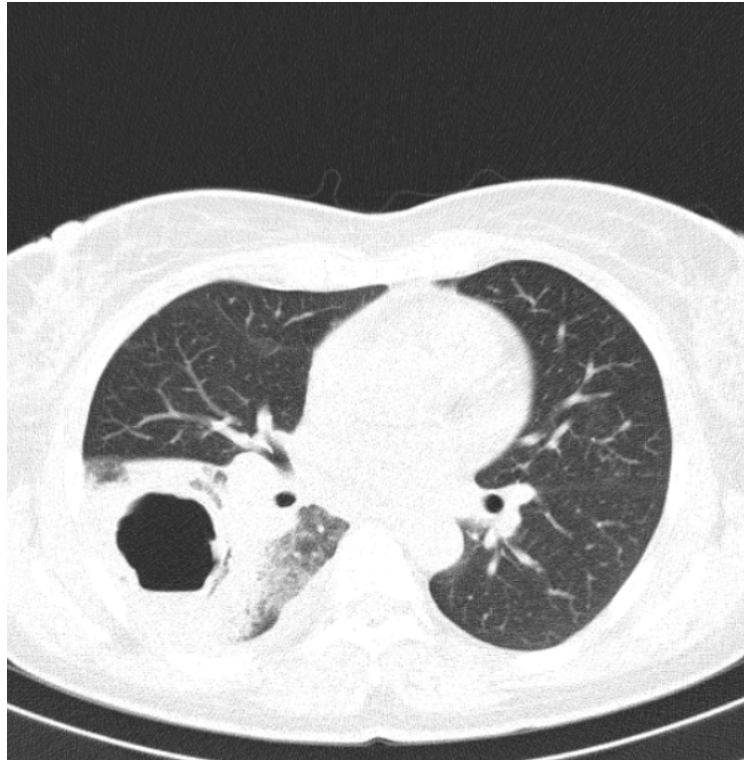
CT scan of the chest showing a cavitary lesion within the lower right lobe surrounded by ground-glass opacities.
